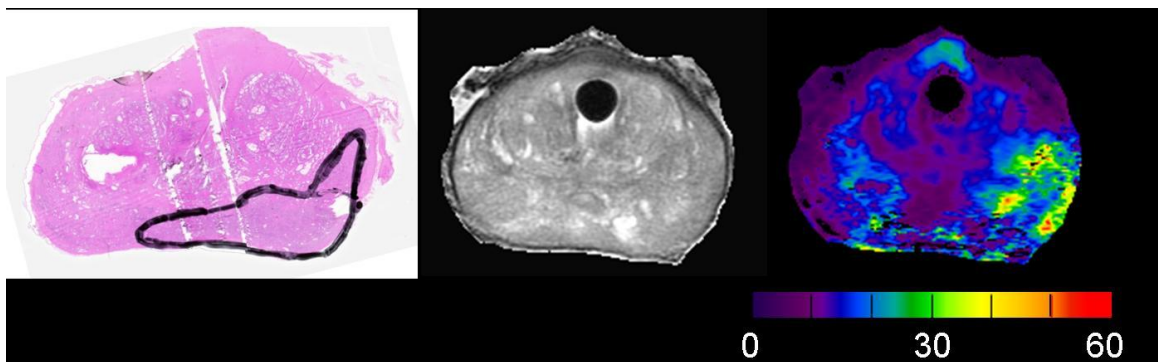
Three images of the same malignant tumor in a prostate tissue sample, shown by a) the black outline in a pathology sample, b) MR image, and c) the yellow-red areas in the MR elastogram (MRE Lab, Mayo Clinic)
